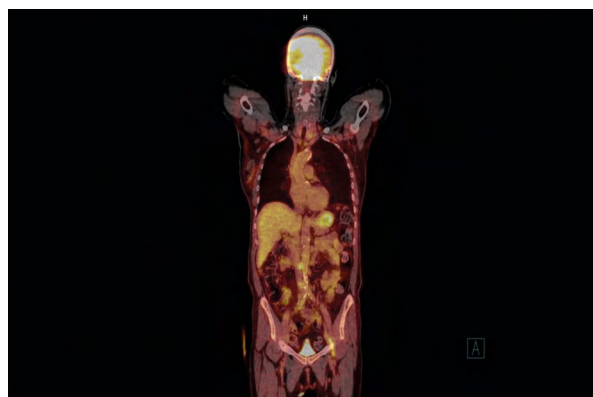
Whole-body PET-CT scan revealing increased metabolism of FDG in right ovarian tube
